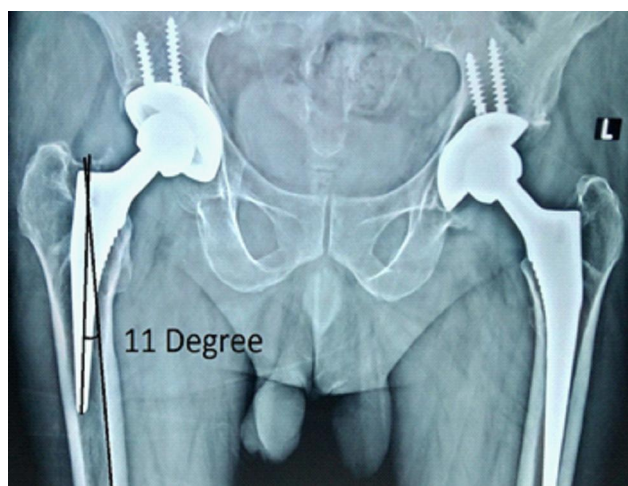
Postoperative anteroposterior radiograph of cementless stem implanted in $> 5^\circ$ of varus. Varus alignment measurement technique, in line with Kahlily and others. Arrow indicates angle in degrees.
